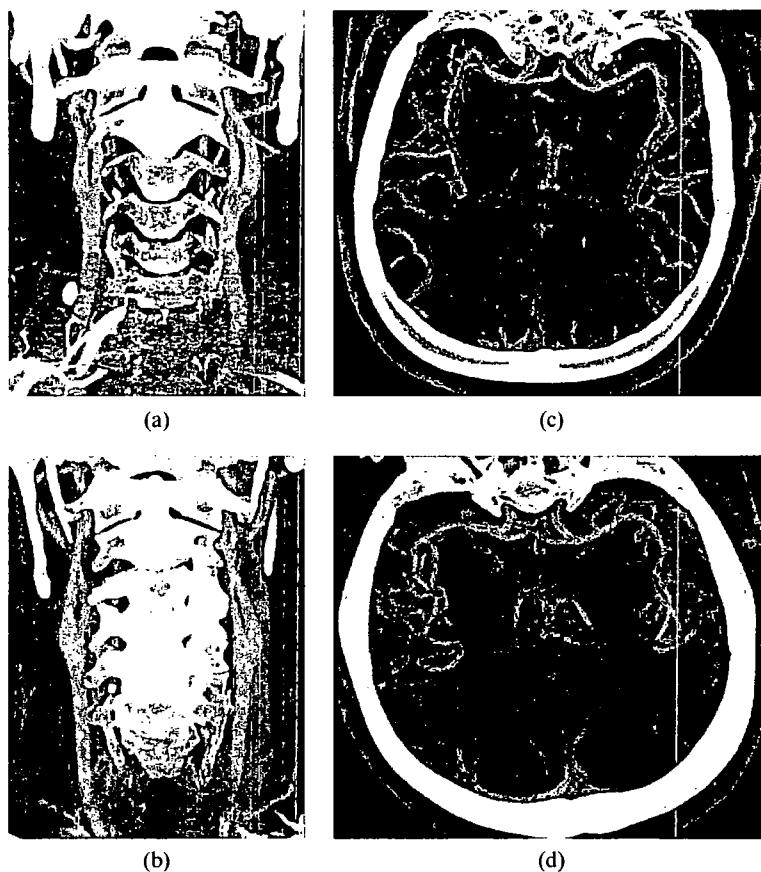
Comparison of cervicocranial three-dimensional CT angiography (3D CTA) image quality. (a,b) Paracoronal thick-slab maximum intensity projections (MIPs) of the carotid arteries. (c,d) Para-axial thick-slab MIPs of the middle cerebral arteries (MCAs). (a,c) 320-slice step-and-shoot incremental 3D CTA. (b,d) Spiral 64-slice 3D CTA. An inferior image quality of the cervicothoracic region is seen on 320-slice CTA, as well as an inferior delineation of the small intracranial MCA-branches in particular.
